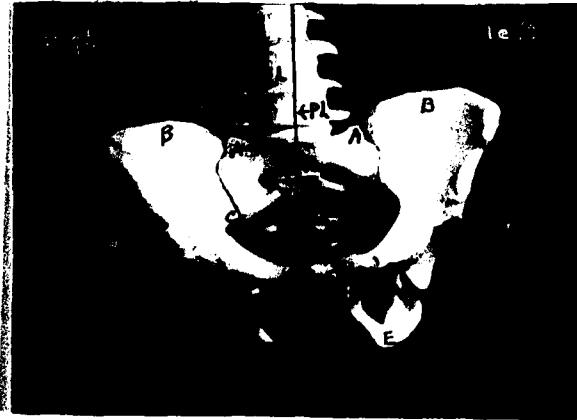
Marked anteroposterior tilt of the pelvis. A shows the inanimate skeletal pelvis with its weight resting anterior to the tuberosities of the ischia; B shows a radiograph of a pelvis similar in appearance in a subject in the standing position.
